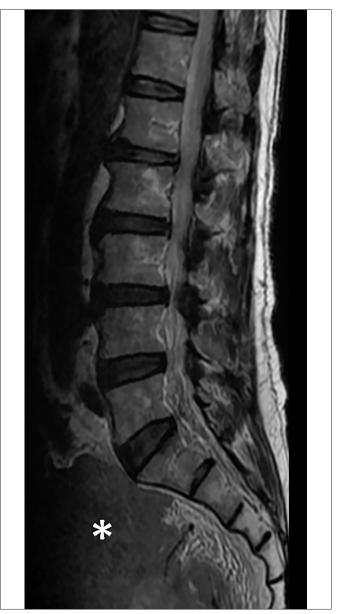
Pelvic mass (asterisk) in the T2-weighted image.
